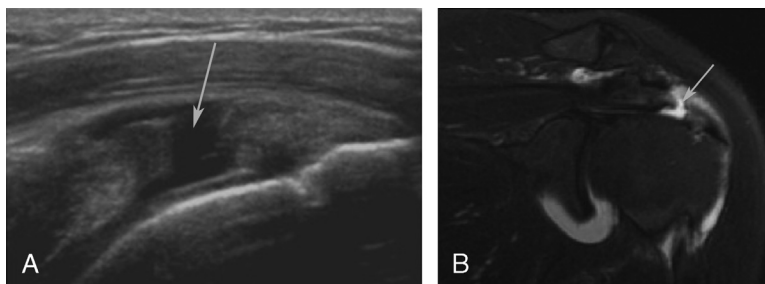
A. Longitudinal ultrasound image of the supraspinatus tendon demonstrates a full-thickness tear (*arrow*) near the footprint. B. MRI in the same patient also shows the full-thickness supraspinatus tear (*arrow*) with nearly identical morphology.
